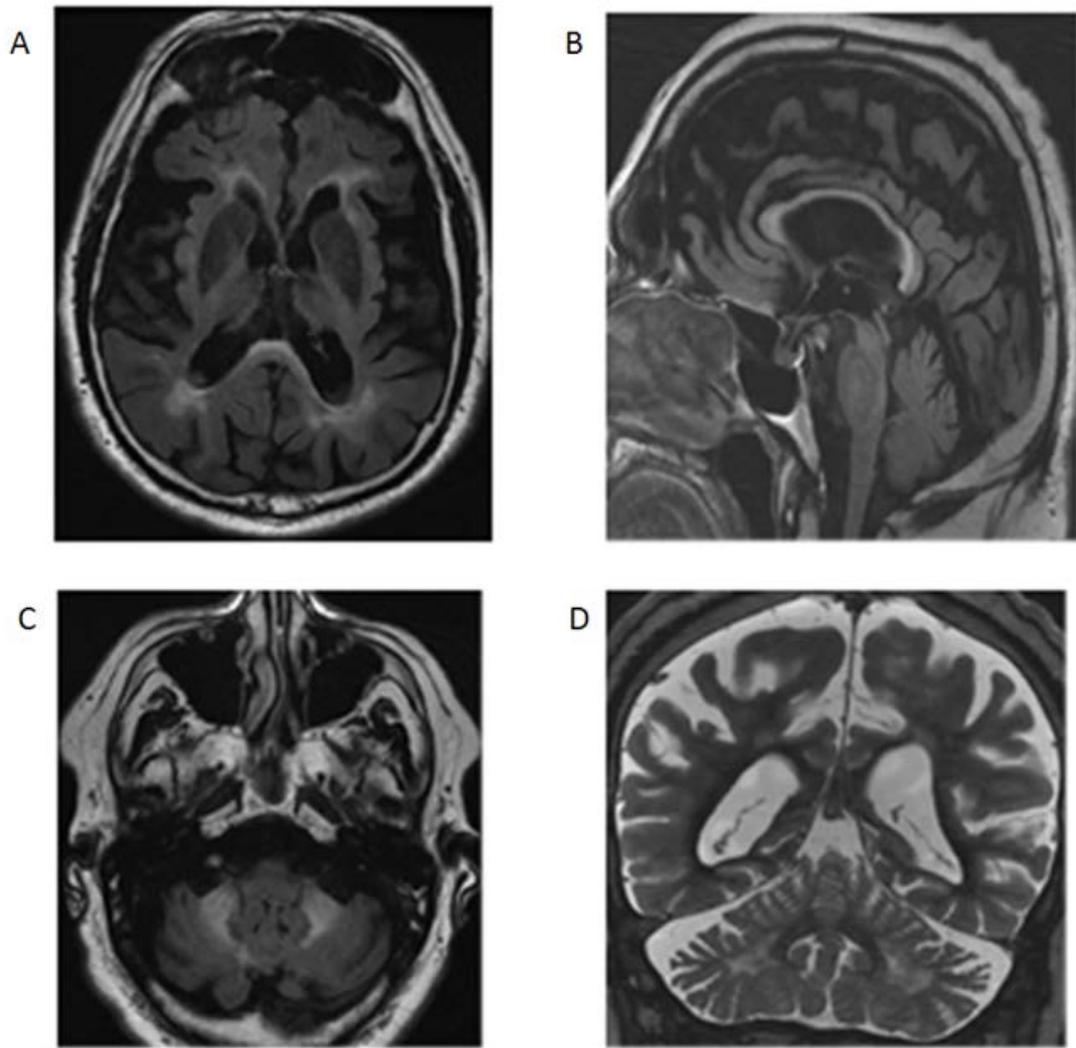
IRM cérébrale avec coupes axiales et sagittale en séquence FLAIR (A, B et C) et coupe coronale en séquence T2 (D) de patients FXTAS: noter l'atrophie cortico-sous-corticale diffuse (A, B et D) avec atrophie du corps calleux (A et B) et cérébelleuse (B et D), l'hypersignal du splénium du corps calleux (A et B), des pédoncules cérébelleux moyens (C) et des noyaux dentelés (D) ainsi que les anomalies sévères de la substance blanche périventriculaire (A).
